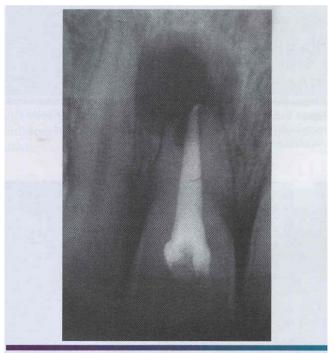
• Periapical cyst. Radiolucency associated with the maxillary central incisor, which exhibits significant root resorption.
